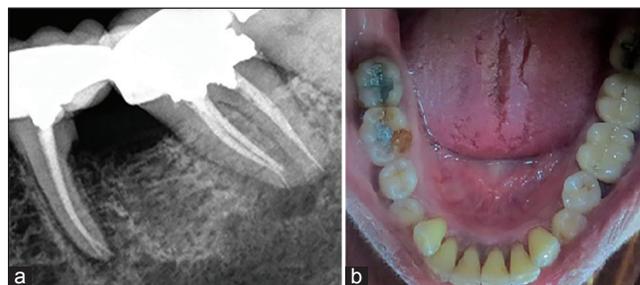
(a) Post operative radiograph (b) Bridge cementation
